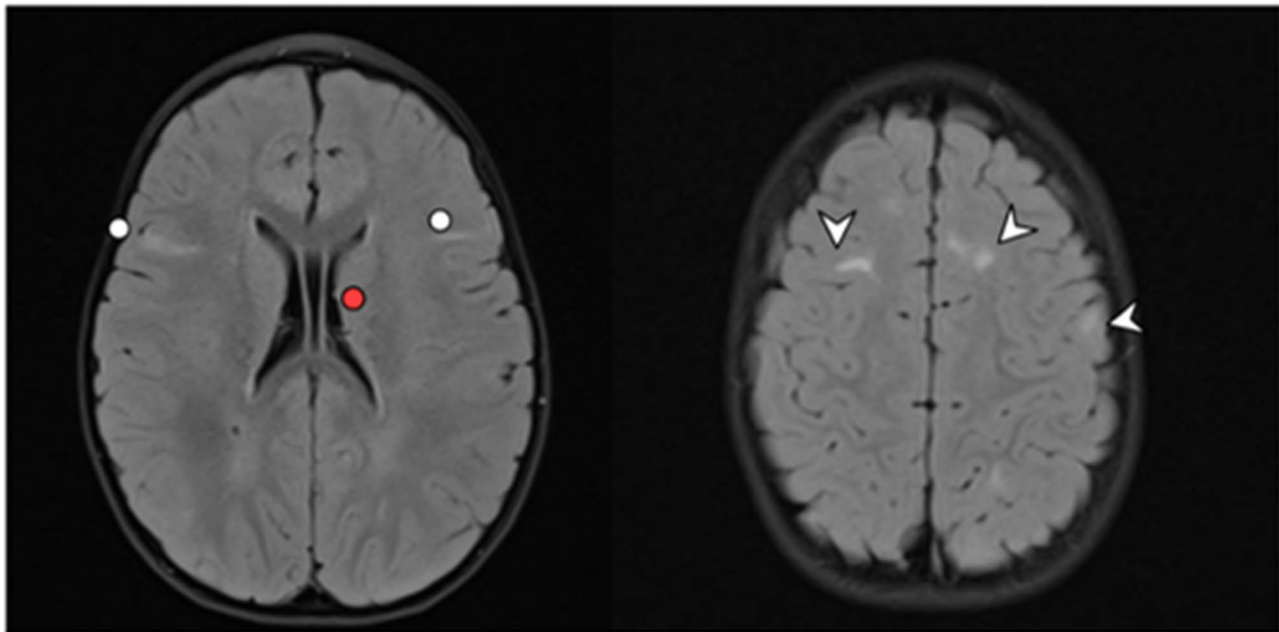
Axial T2 fluid-attenuated inversion recovery (FLAIR). The image on the left shows linear white matter lesions located bilaterally (white dot) and small subependymal nodules along lateral ventricles (red dot). The image on the right shows cortical and subcortical tubers located bilaterally along the frontal-temporal-parietal lobes (white arrow)
